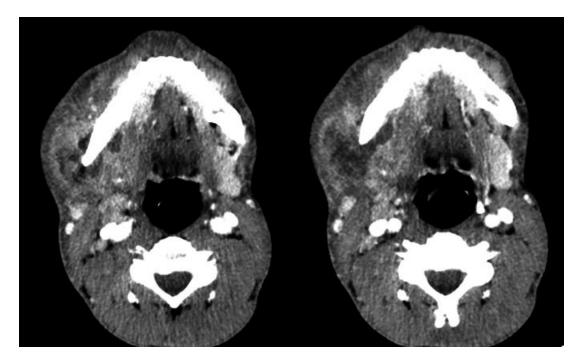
Axial CT scans demonstrating acute odontogenic infections occupying the Rt. submasseteric and pterygomandibular spaces.
